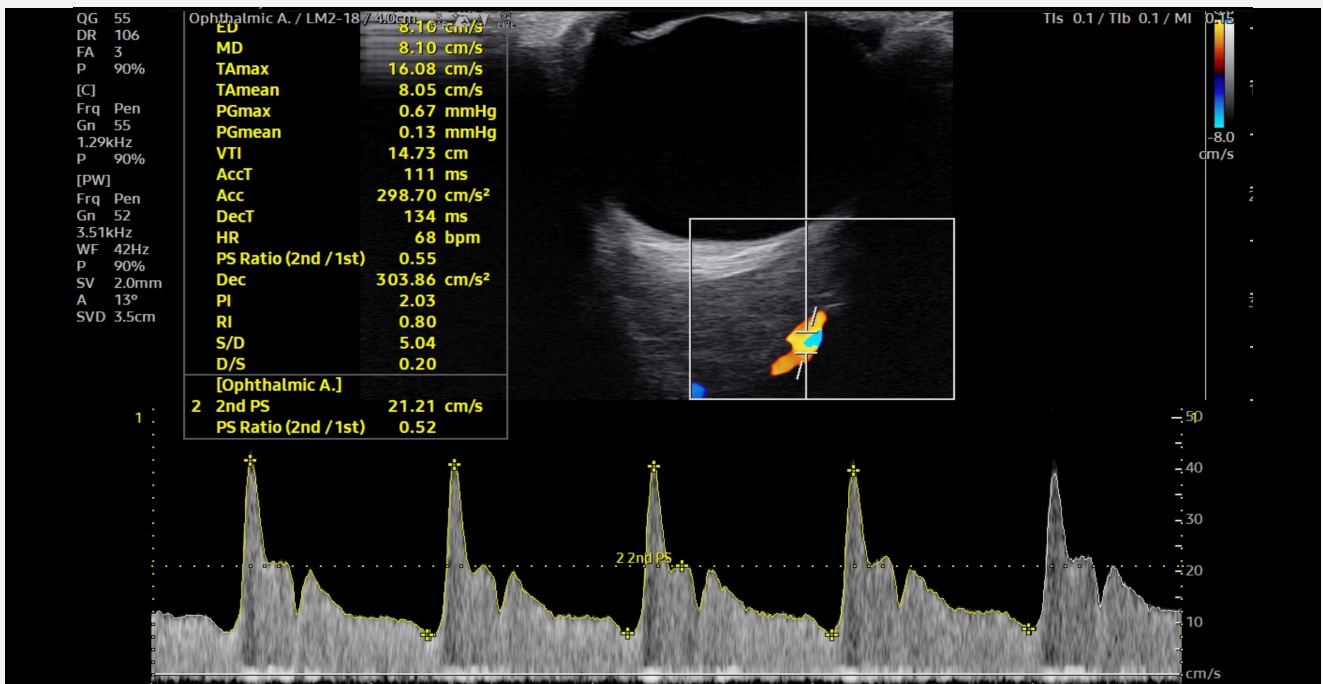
Doppler waveform with automatic tracing of the waveform and auto calculation PS Ratio, first PS, EDV, PI and RI
